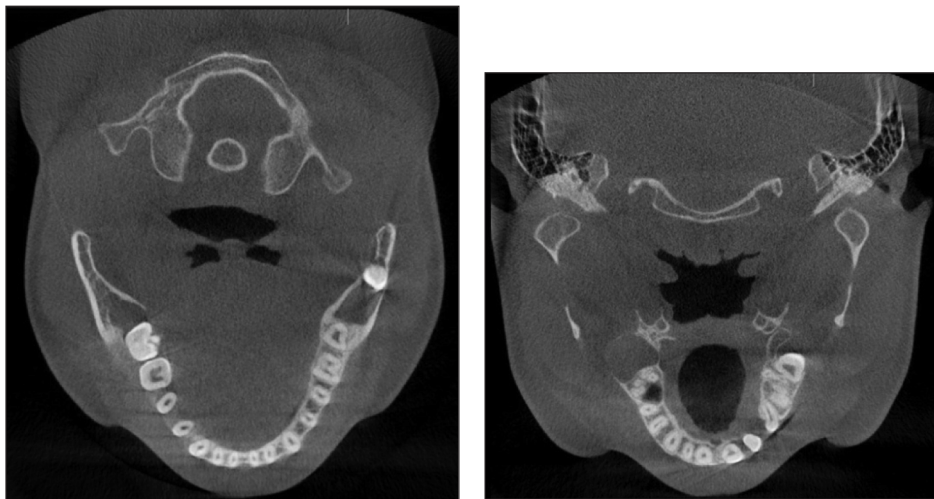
a) Bilateral mandibular hypodense lesions in the axial section of CBCT. b) Hypodense lesion in the tuberosity of the right maxilla in the axial section of CBCT.
